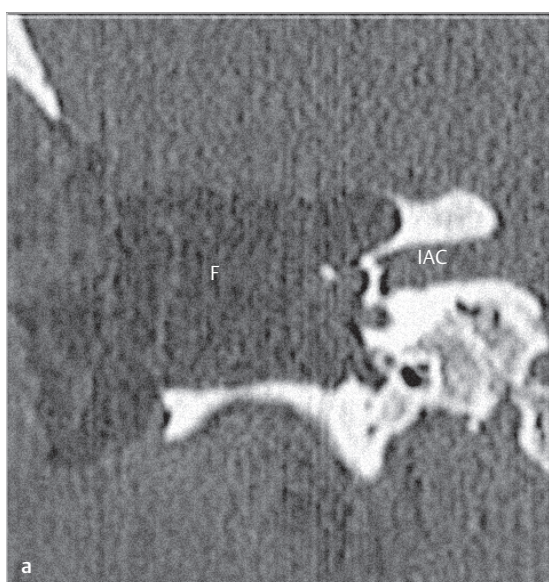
The postoperative coronal CT (a) and MRI (b) show extensive removal of the middle fossa plate to establish wide access to cholesteatoma from superior. Note that the fundus of the internal auditory canal is not insulated. F, abdominal fat; IAC, internal auditory canal; TL, temporal lobe.
